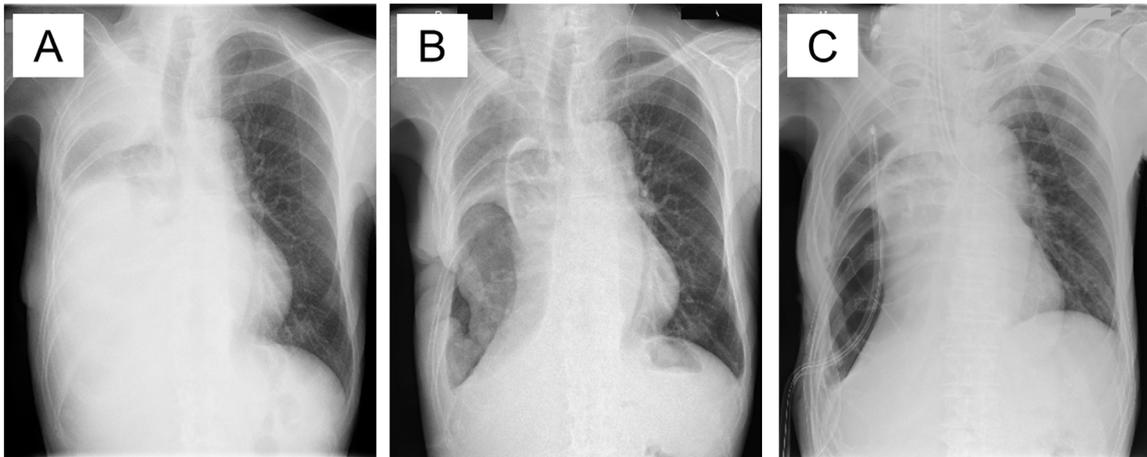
A): Chest X-ray disclosing an expansion failure of the right upper lobe and a large space in thoracic cavity. B): Open window thoracostomy was performed. C): The window of the chest wall was closed and a chest tube was placed in the empyema cavity.
